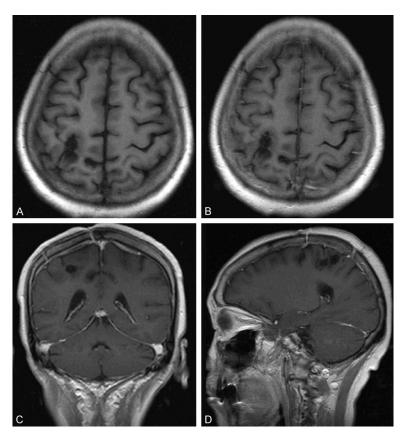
Axial T1-weighted MRI (A), Axial, Sagittal and Coronal T1-weighted gadolinium-enhanced MRI image shows there is no evidence of the tumor existing at the 12-month follow-up (B-D).
